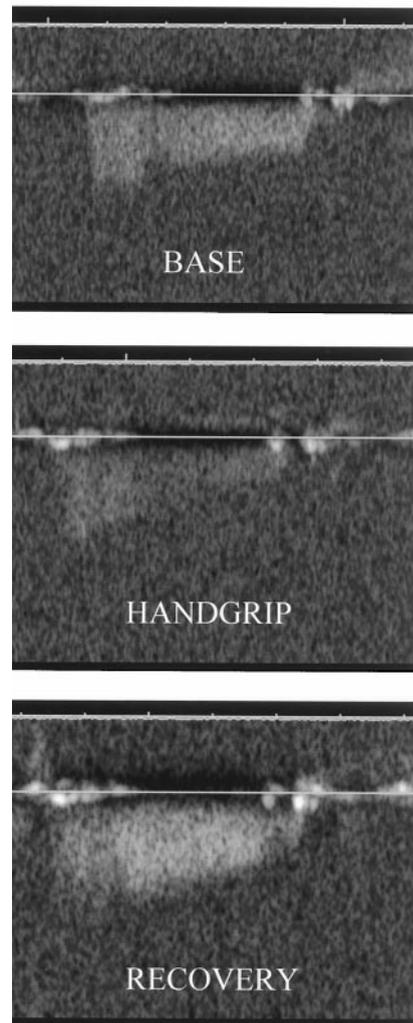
Coronary Doppler tracing during 30-s handgrip in a patient with significant LAD disease. The Doppler intensity is reduced during handgrip, probably due to coronary vasoconstriction, and is slightly increased at recovery, probably due to reactive hyperemia. Flow velocities remain unchanged during handgrip, but there is a slight increase at recovery.
